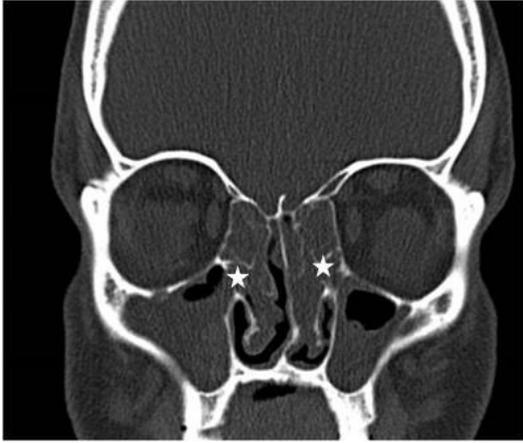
Coronal CT scan shows osteomeatal complex blockage (white stars) with bilateral chronic maxillary sinusitis and ethmoidal complex sinusitis.
